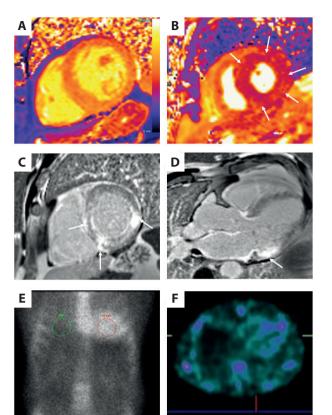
Native T1 color map with elevation of the septal T1 values on the mid-short-axis view (A); T2 systolic color map with diffuse T2 elevation on the mid-short-axis view (B; arrows); Late gadolinium enhancement imaging demonstrating extensive enhancement in the basal inferoseptal, inferior and inferolateral walls on the basal short-axis (C) and 3-chamber views (D); 3-hour technetium-99m pyrophosphate scintigraphy with the heart/contralateral lung ratio of 1.99 (E) and grade 3 myocardial uptake on technetium-99m pyrophosphate single-photon emission computed tomography (F)
